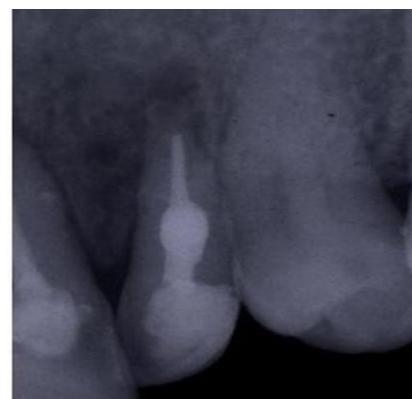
1-year follow-up radiograph
